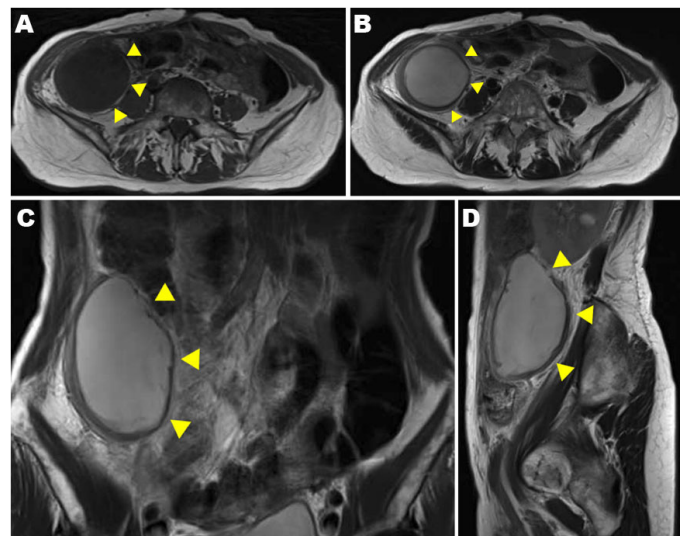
MRI images. Arrowhead: Tumor. MRI images on admission (A: T1-weighted; B–D: T2-weighted). The intracystic area showed low signal intensity on T1-weighted images and high signal intensity on T2-weighted images.
